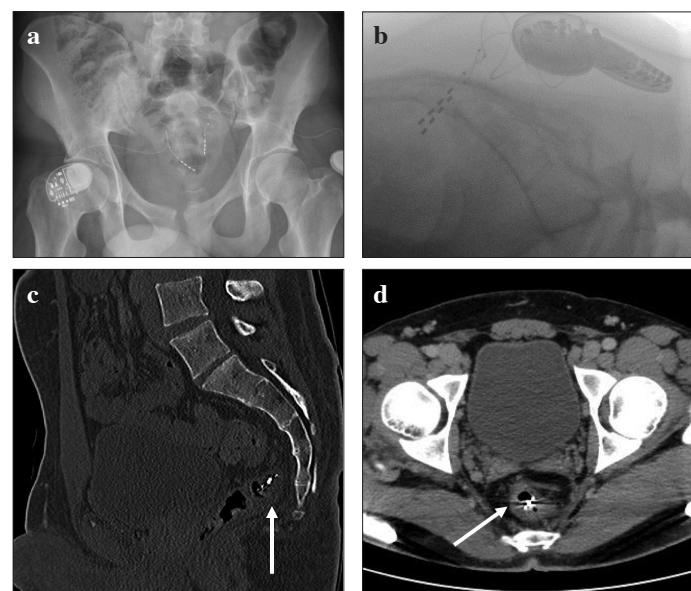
a-d. Anterior/posterior x-ray showing a too deep and medial projection of the right lead (a), lateral intraoperative fluoroscopic imaging proving a correct localization of both leads (b), CT-Scan imaging with sagittal (c), and axial view (d) of bilateral sacral neuromodulation device with a displacement of the right-sided lead in the rectum (arrows)
